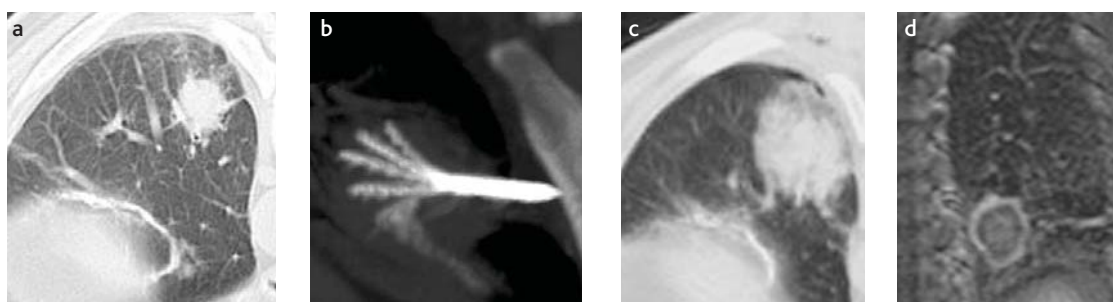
Lung tumour treated with radiofrequency ablation. Pre-treatment CT shows the focal mass (a). CT obtained after electrode placement confirms proper deployment (b). CT after the ablation shows ground-glass density area encompassing the native tumour as well as a safety margin of surrounding lung parenchyma (c). T1-weighted gadolinium-enhanced MR imaging confirms complete ablation by showing a non-enhancing hypointense area of coagulation necrosis surrounded by a thin enhancing rim representing inflammatory reaction (d).
